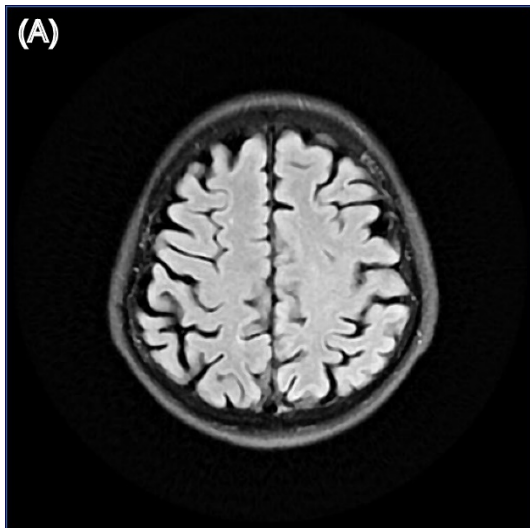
Structural brain MRI images of patient 26. (A) T2-weighted fluid-attenuated inversion recovery (T2-FLAIR) image; (B) Gadolinium-enhanced T1-weighted (Gd-T1w) image.
